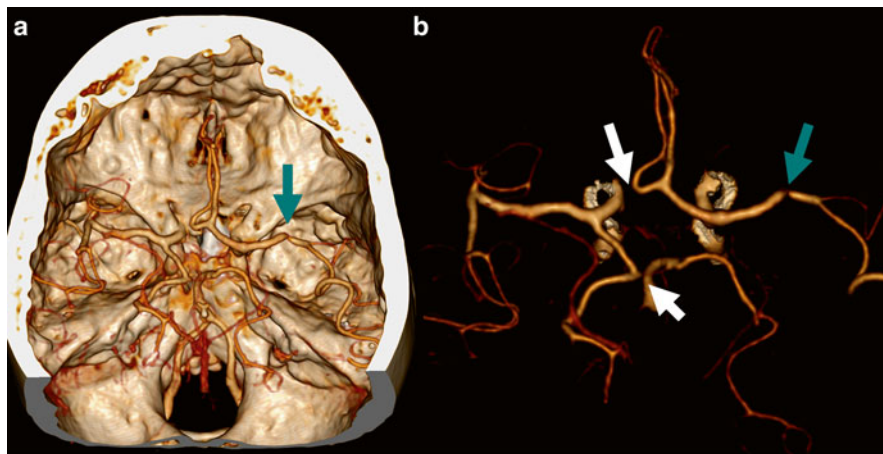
A 84 y/o female presented with right-sided hemiparesis and aphasia due to a left MCA territory stroke. CTA demonstrated a left MCA stenosis (*blue arrow*). As normal variant, hypoplasia of the right A1 segment is present, as well as hypoplasia of the P1 segment (*white arrows*). Volume rendering (VR) (a) and VR after bone removal (b) from DECTA are shown
